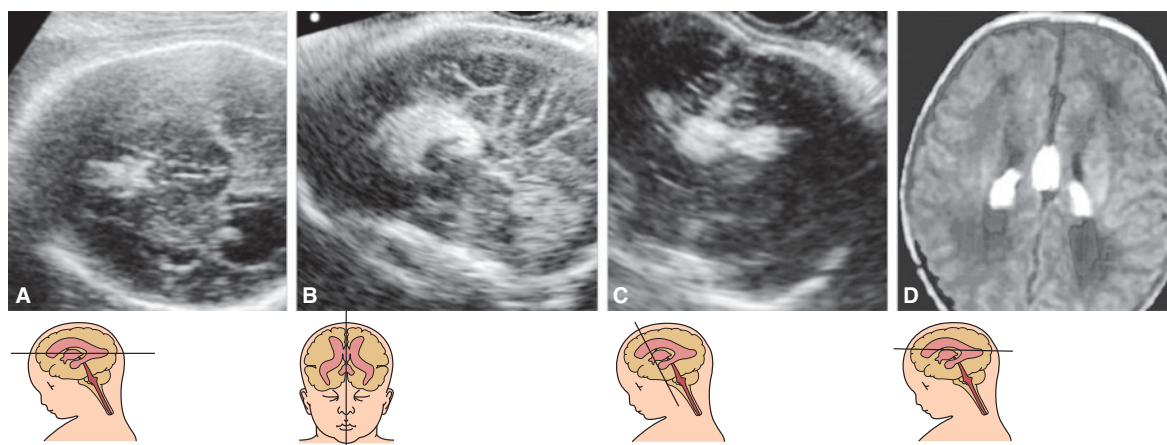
Agenesis of the corpus callosum with lipomas. In some cases, there is lateral extension of the midline lipomatous process to involve the choroid plexuses of the lateral ventricle. (A–C) Prenatal ultrasound. (D) Postnatal CT.
